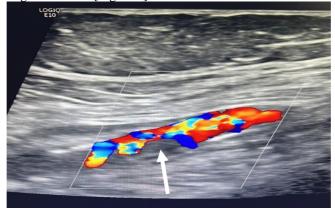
Duplex Ultrasound showing cystic adventitial lesion causing intra-luminal narrowing of popliteal artery (white arrow).
